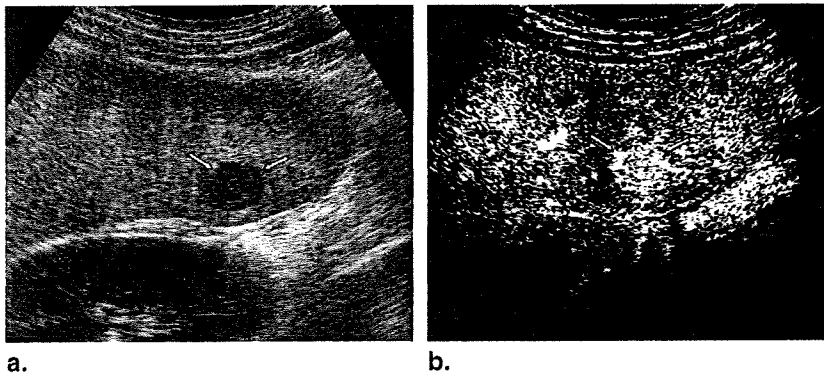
A 28-year-old man with alcoholic cirrhosis and hepatocellular carcinoma (*arrows*). (a) Sagittal B-mode ultrasound shows hypoechoic mass (*arrows*) in right lobe of liver. (b) In arterial phase, lesion (*arrows*) shows diffuse homogeneous and slightly hypervascularity relative to liver parenchyma. Percutaneous biopsy revealed well-differentiated hepatocellular carcinoma.
